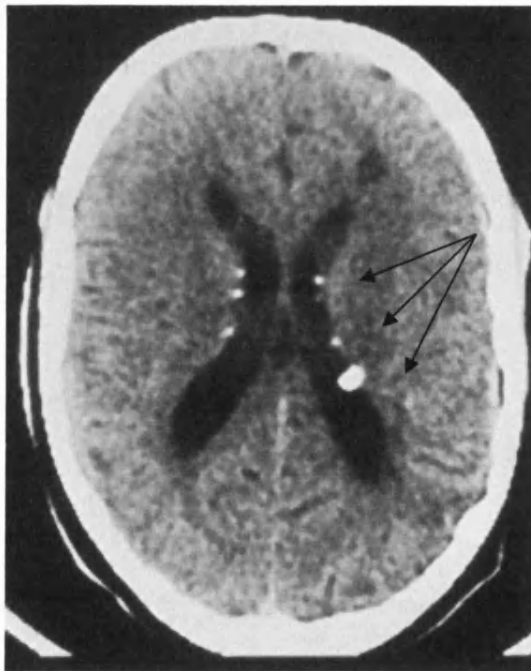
Figure nine – Subependymal nodules (CT scan)
